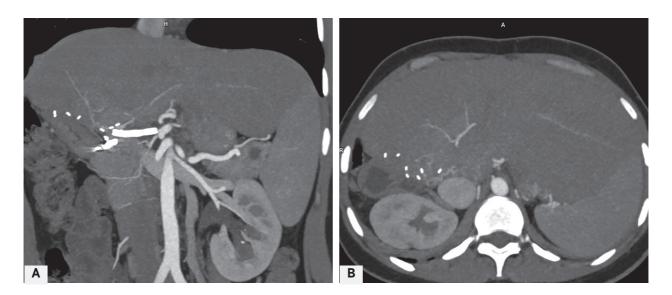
(A, B) Coronal and Axial Maximum Intensity Projection Computed Tomography Images Showing Occlusion of Hepatic Artery at Anastomotic Site, With Many Small-Caliber Collaterals Filling the Intraparenchymal Hepatic Artery Branches
